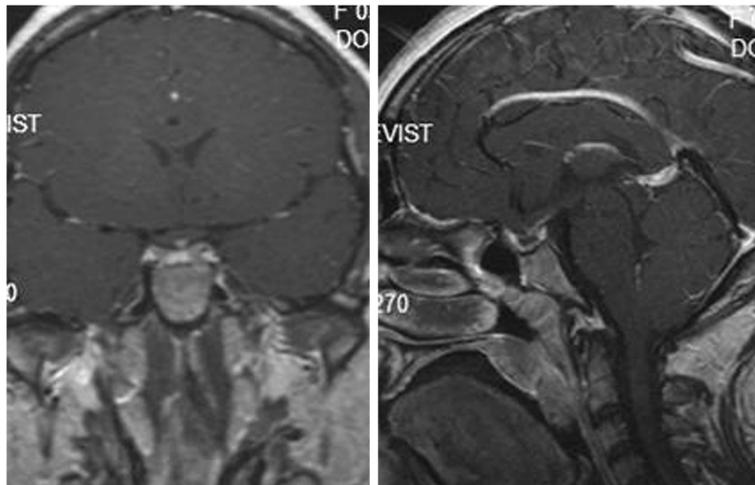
T1-weighted coronal (left) and sagittal (right) MRI with contrast demonstrated the sel-lar/suprasellar mass lesion was disappeared 3 months after surgery
